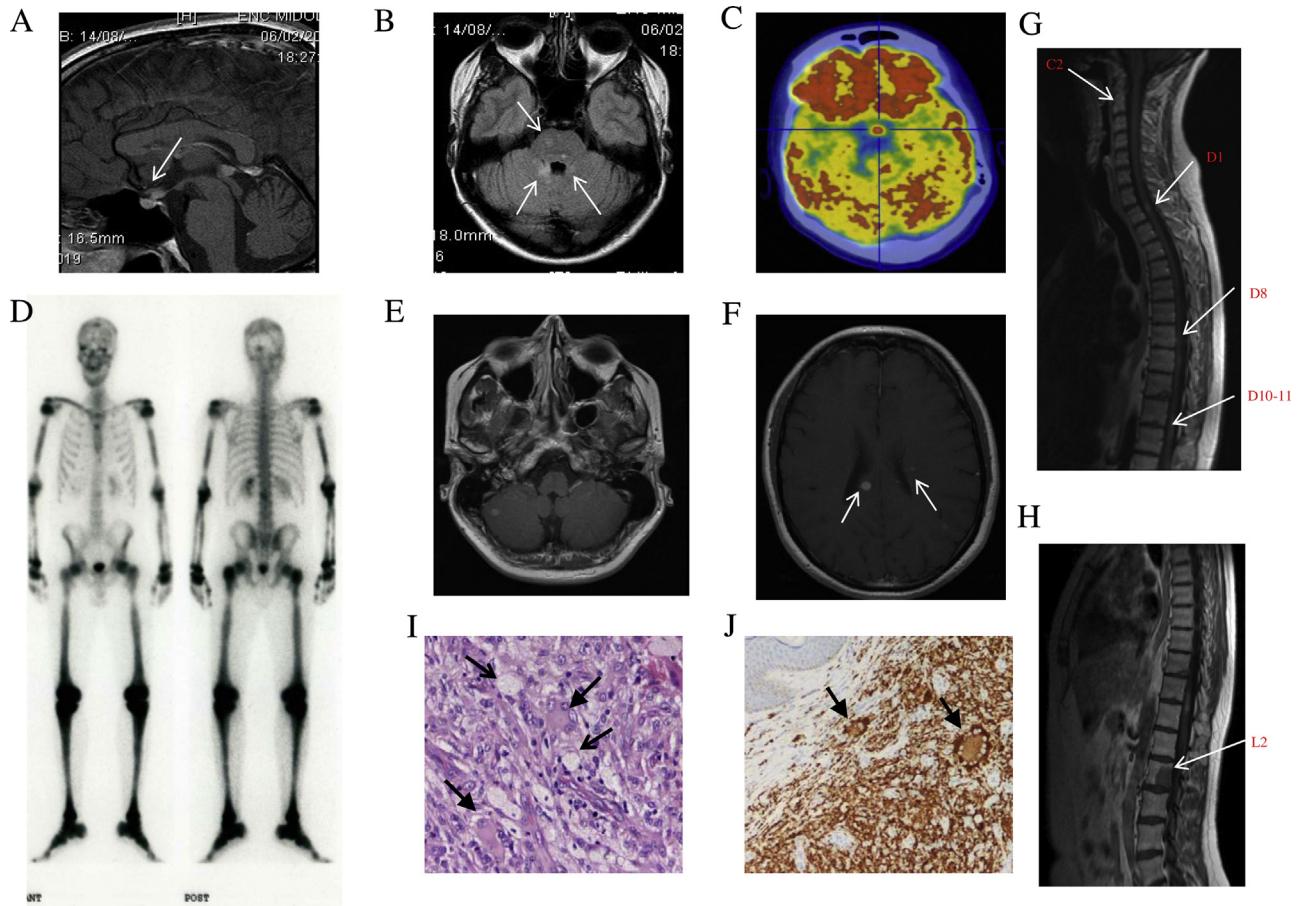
Bone and CNS involvement in our own observation of ECD. At diagnosis, MRI detected an intense enhancement of the infundibular stalk after gadolinium administration (A) and the presence of white matter lesions in the pons and in the right middle cerebellar peduncle (B). Fused PET/CT image (C) showed increased FDG uptake in the pituitary gland. ^{99}Tc bone scan showed increased uptake in the proximal epiphysis and metaphysis of long bones (D). After one year of treatment with cyclophosphamide and steroids, the patient underwent worsening in the CNS involvement, with new cerebellar (E) and peri-ventricular lesions (F). Also, spinal (G) and vertebral (H) lesions were detected. CD68+ small nucleated foamy histiocytes (arrow) and Touton-like multinucleated giant cells (arrowhead) in a skin lesion biopsy (I–J).
